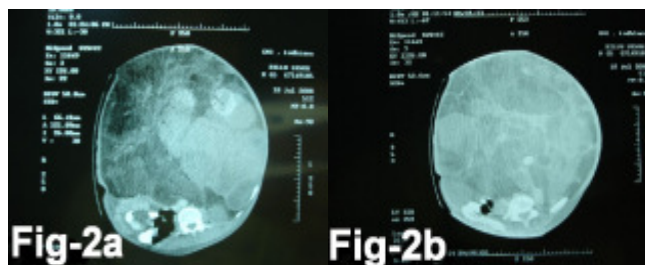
CT Scan Showing Giant Lipomatours Mass Displaying Small Gut Towards Right Corner
